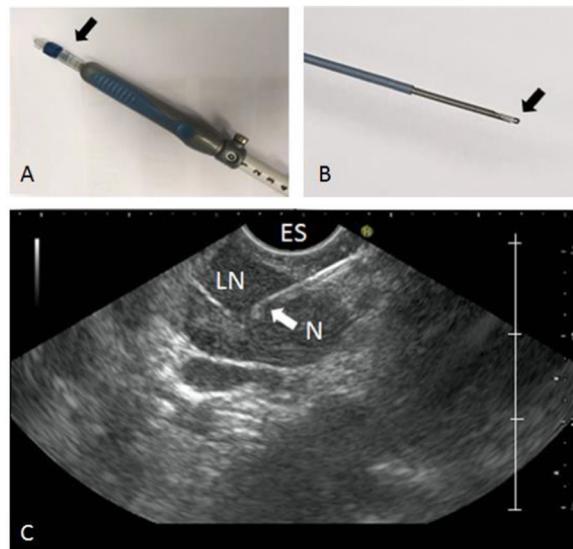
A- Locking of the CLE probe to the aspiration needle. B- CLE probe inside endosonography needle. C- Endosonography images of n-CLE measurements (white arrow) inside a lymph node (LN) (Wijmans/Annema et al. [10]).
